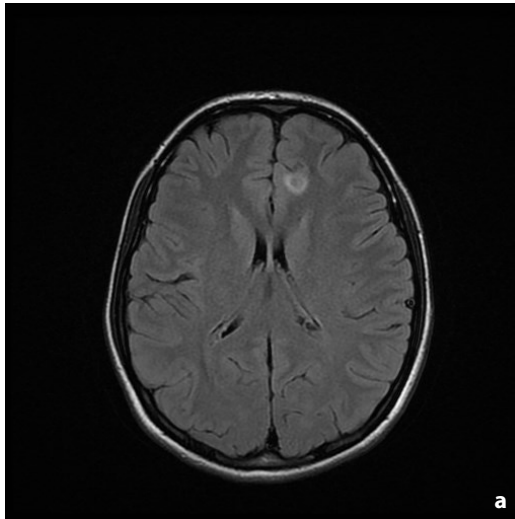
a) Brain MRI performed on 10th November 2014, Axial T2 showing a solitary lesion without contrast enhancement. (Flair Axial). b) Preoperative brain MRI showing enlargement of the lesion to more than 7 cm in AP diameter and its compressive effect on surrounding structures. c) The emergence of new zones of changed signal intensity in the left frontoparietal region immediately next to the extensive zone of signal intensity changes, with perifocal edema in the left frontoparietal supraventricular region, and right parietal parasagittal region. There is an impression of discrete reduction in the peripheral edema extension, but also of the same extension of the tumefactive lesion to the left (DWI).
